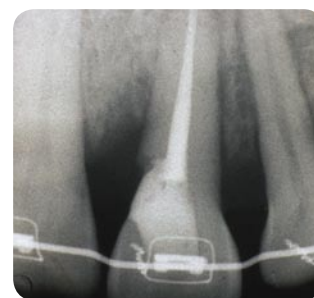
Radiographic view of tooth No. 9 shown on Figure 12a three weeks after forced eruption through conventional orthodontics. Compare the relationship between the resorption area and the interproximal bone crest prior to the extrusion (Figure 12b) and after the extrusion.
